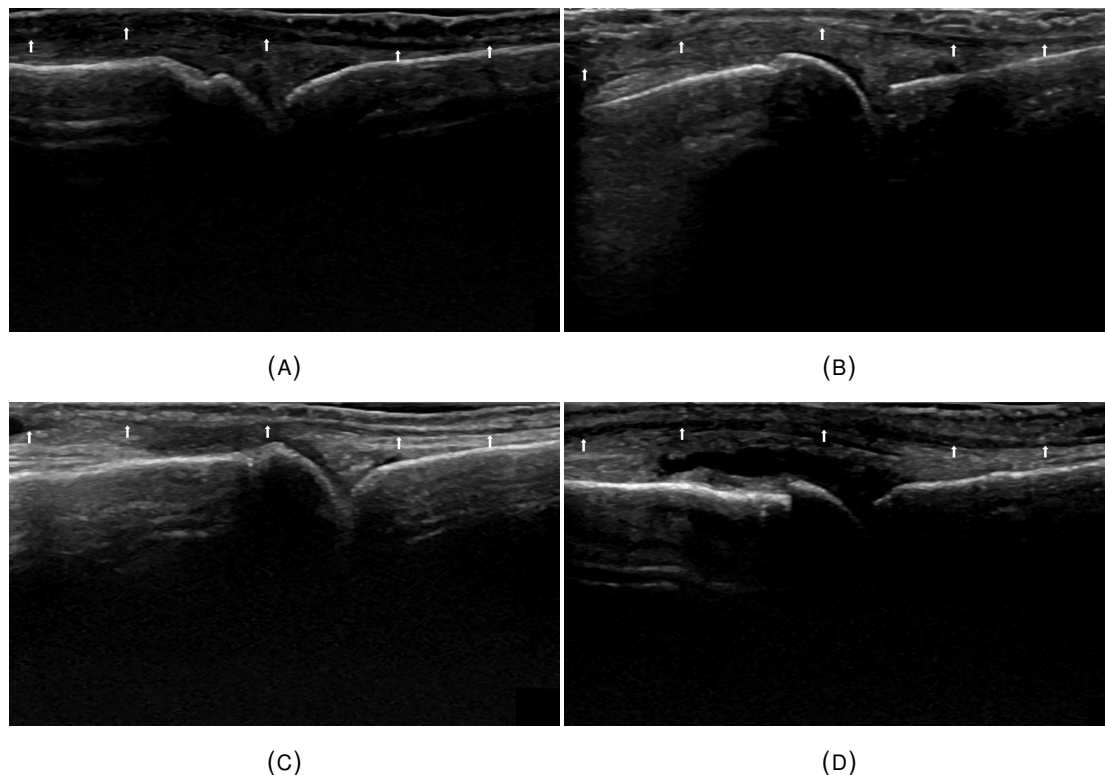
Examples of ultrasound images of the dorsal view of the second MCPJ. The white arrows indicate the position of the extensor tendon.
